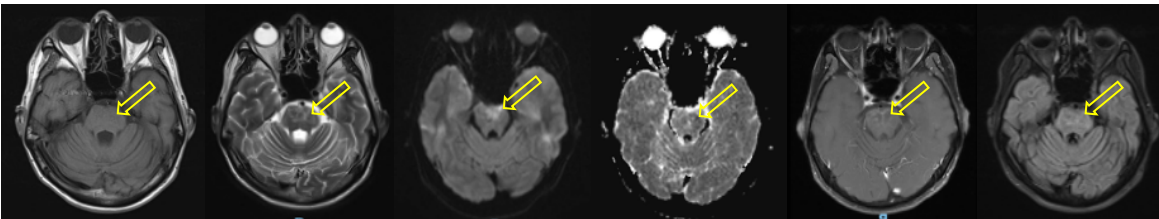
Baseline Cranial MRI plain and contrast: (A) T1 hypointense, (B, F) T2W/FLAIR iso- and hyperintense signals with restricted diffusion on (C) DWI and corresponding signal drop in (D) ADC irregularly contrast-enhancing border that
